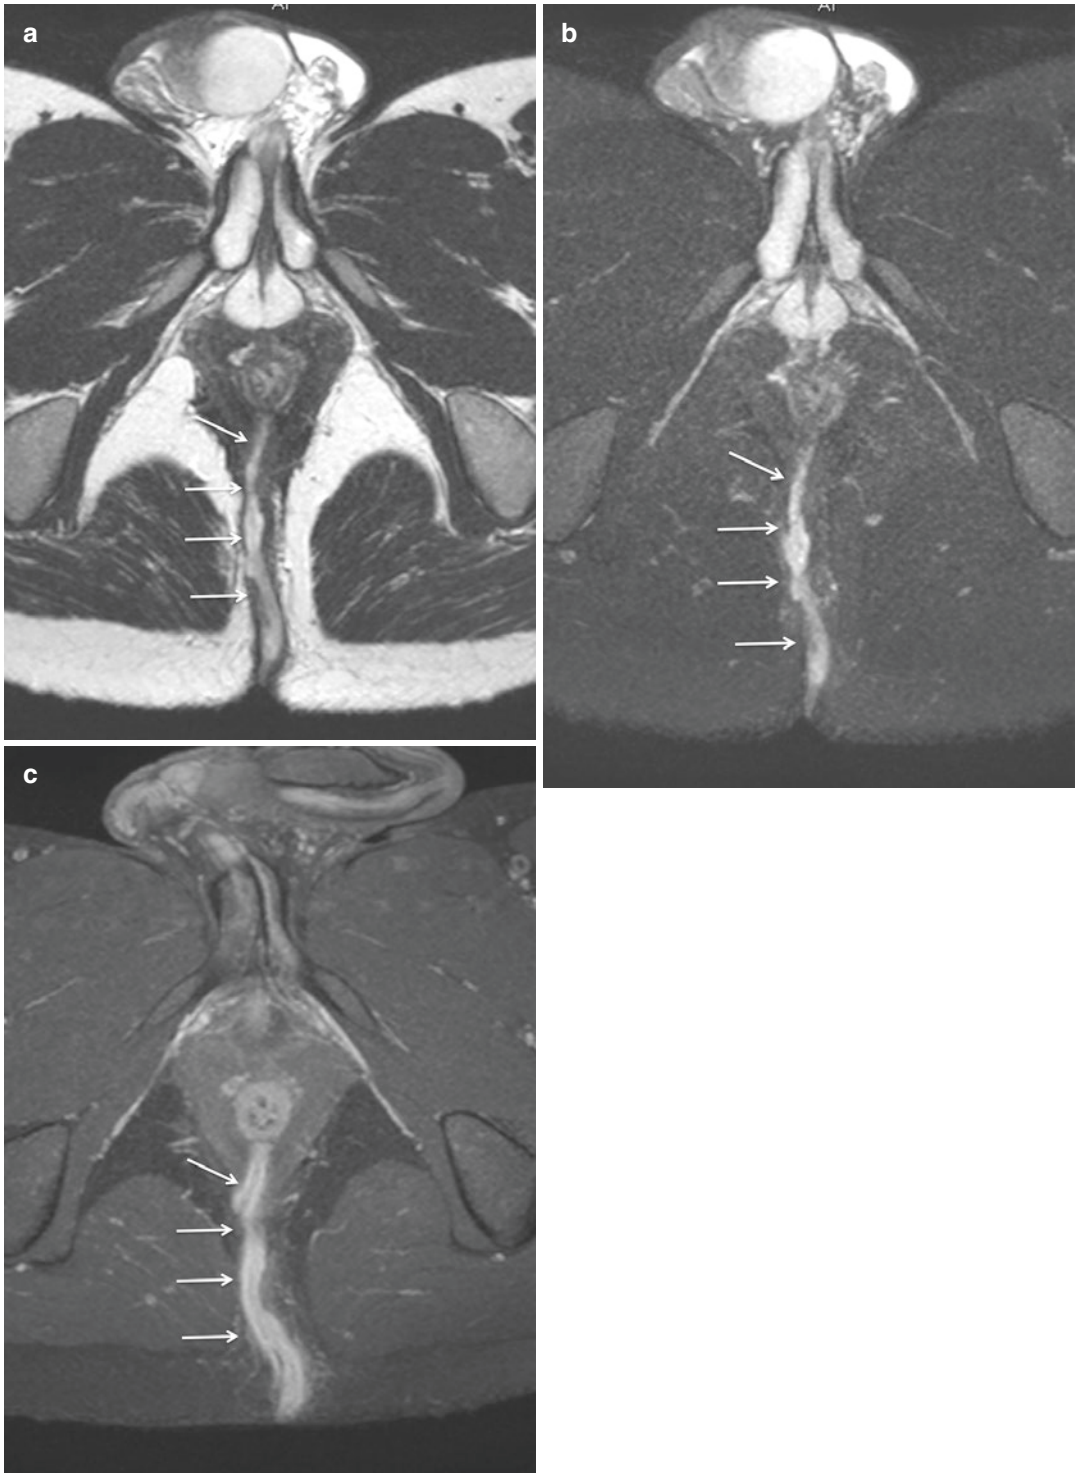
Trans-sphincteric fistula. Axial-oblique T2-weighted TSE images performed without (a) and with fat saturation (b) show a posterior midline hyperintense
